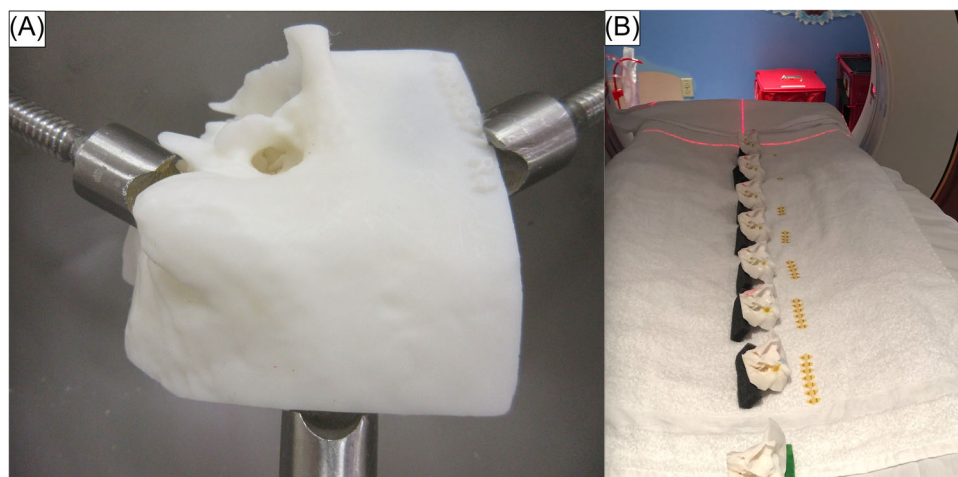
Pediatric temporal bone model is drilled into multiple stepwise models. (A) A photo of the undrilled 3D-printed temporal bone model created from a CT scan of a 7-year-old patient. (B) Once the stepwise models were created by the attending neurotologist, they were CT scanned. Multiple models could be scanned at once and differentiated from each other by yellow CT markers. 3D, 3-dimensional; CT, computed tomography.
